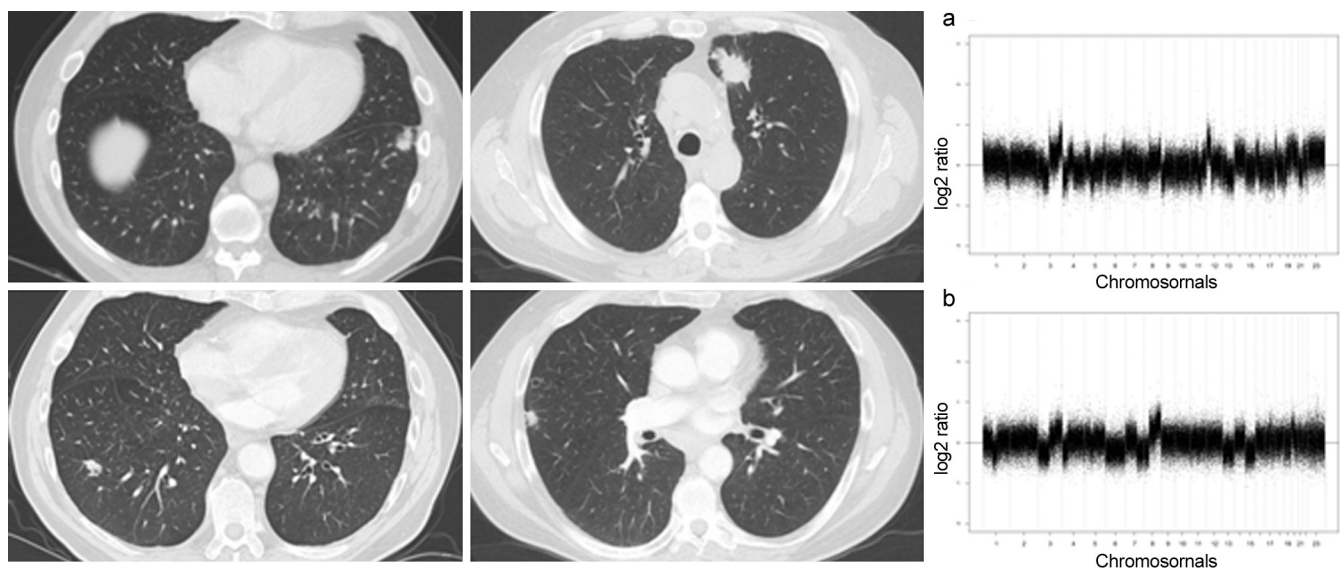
Panel showing serial CT scans and array CGH in patient 1. Lesion in the upper left panel was treated in 2008, upper middle panel 2013, lower left panel 2013, lower middle panel 2015. Array CGH image of SqCC vocal cord 1996 (a, upper right) and SqCC right lower lobe 2013 (b, lower right) showing differences in patterns of chromosomal gains and losses that were consistent with different tumors. The vertical axis represents normalized log₂ ratios of tumor versus normal and the *x*-axis represents the ratios ordered by genomic position from chromosome 1 to X. Profiles dewaved using *r*-script nowaves (van de Wiel et al. [21]).
